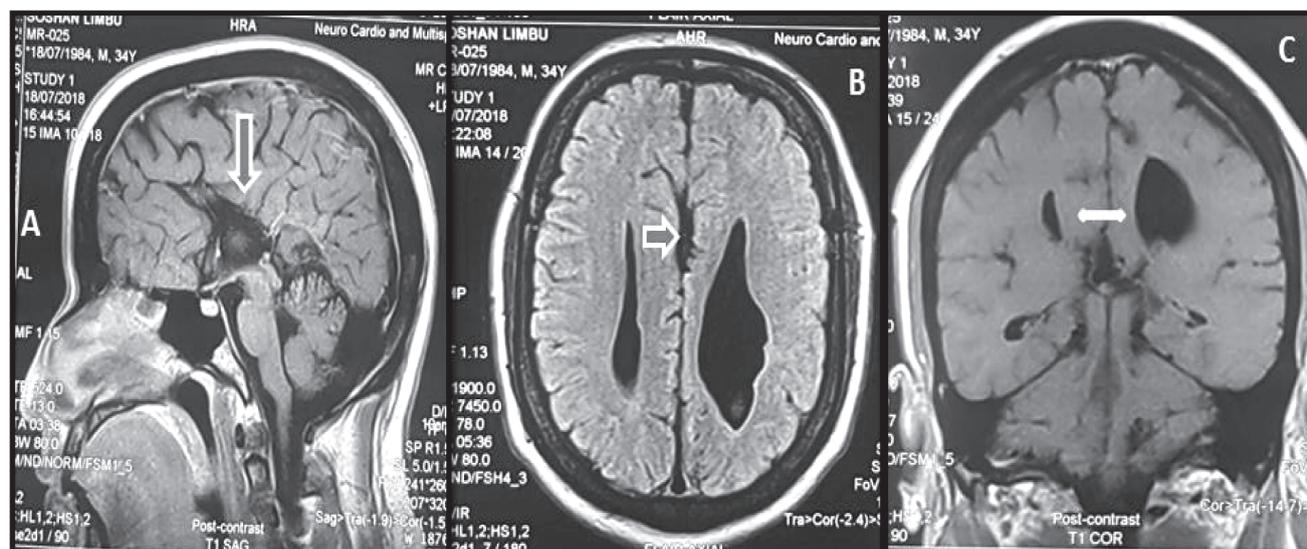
MRI showing Complete CCA with high riding third ventricle (arrow) on sagittal section (A), parallel asymmetrical ventricles with Probst fibres in Axial section (B) and bull horn appearance of ventricle in coronal section with Probst fibres (arrow) (C).
